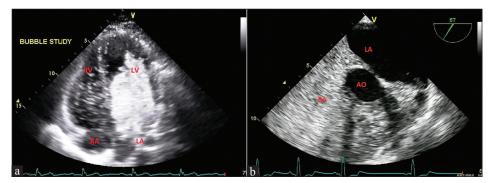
(a) Transthoracic echocardiogram bubble study with agitated saline injected intravenously through the left arm showing a large bolus of bubbles entering into the left atrium (LA). (b) Transesophageal echocardiogram bubble study with agitated saline injected intravenously through the right arm revealed complete opacification of the LA with bubbles in the right atrium. Abbreviations; Right ventricle (RV), Left ventricle (LV), Aorta (AO)
